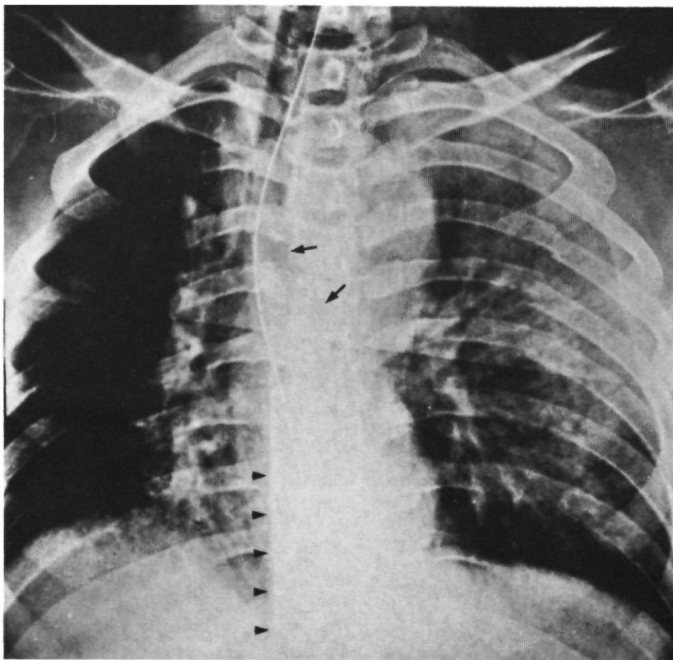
12 Male, 18 years, vertical deceleration, TAR. Death on the 9th postoperative day due to cerebral injury. Chest X-ray: widening of the right paraspinal line (triangles). Note also displacement of the trachea and nasogastric tube (arrows). Depressed left main bronchus. Widened mediastinal shadow (12 cm). Unsharp aortic contour. Pulmonary contusion of the left side with multiple fractures.
